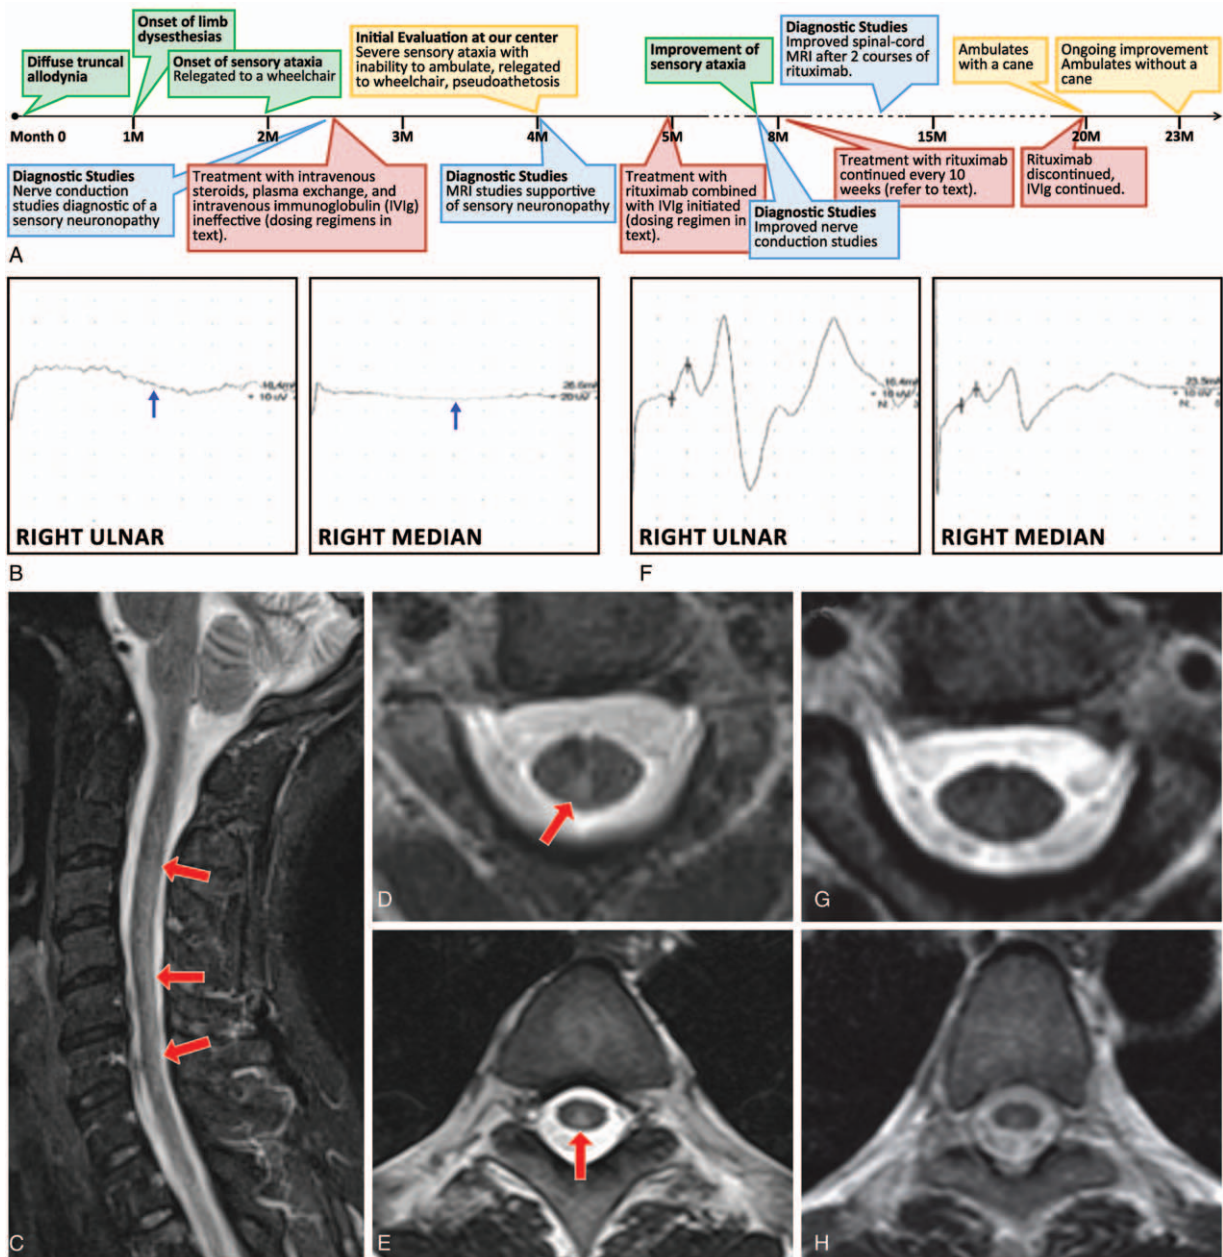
Timeline of disease, nerve-conduction, and neuroimaging studies in a sensory neuropathy patient treated with rituximab combined with intravenous immunoglobulin. (A) Timeline of patient's symptoms, diagnostic studies, and response to treatment. (B) Prior to treatment, the sensory nerve action potentials (SNAPs) have a flat contour and are not elicited for the right ulnar sensory nerve (left panel) and right median sensory nerve (right panel). Such diffuse loss of SNAPs is characteristic of a sensory neuropathy, and is also an electrodiagnostic indicator of large-sized, dorsal root ganglia neurodegeneration. Pretreatment MRI studies (C–E): Sagittal T2-weighted sequence shows hyperintense lesions, which are longitudinally extensive in the cervical and thoracic cord (red arrows) (C). Axial T2-weighted sequences show hyperintense lesions in the dorsal columns (red arrow), affecting the cuneate fasciculus as well as the gracile fasciculus in the cervical (D) and thoracic cord (E). In addition, on axial T2-weighted sequence of the cervical spinal-cord, there is asymmetric, hyperintensity affecting the right more than the left dorsal column (D). After 1 course of treatment, SNAPs can now be elicited from the right ulnar (left panel) and right median (right panel) sensory nerves (F), corresponding to patient's improvement on neurological examination and MRI studies. Post-treatment MRI studies (G and H): after 2 courses of treatment, axial T2-weighted sequences show interval decrease in dorsal column hyperintensities in the cervical (G), as well as thoracic cord (H). MRI = magnetic resonance imaging.
